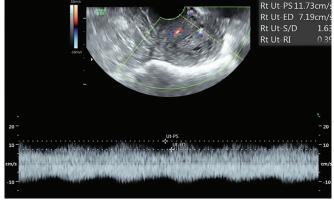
The same patient assessed with color Doppler ultrasound. Pulsed Doppler waveform analysis reveals low resistance flow (resistance index 0.39). Increased vascularity with low vascular impedance is suggestive of endometrial malignancy
